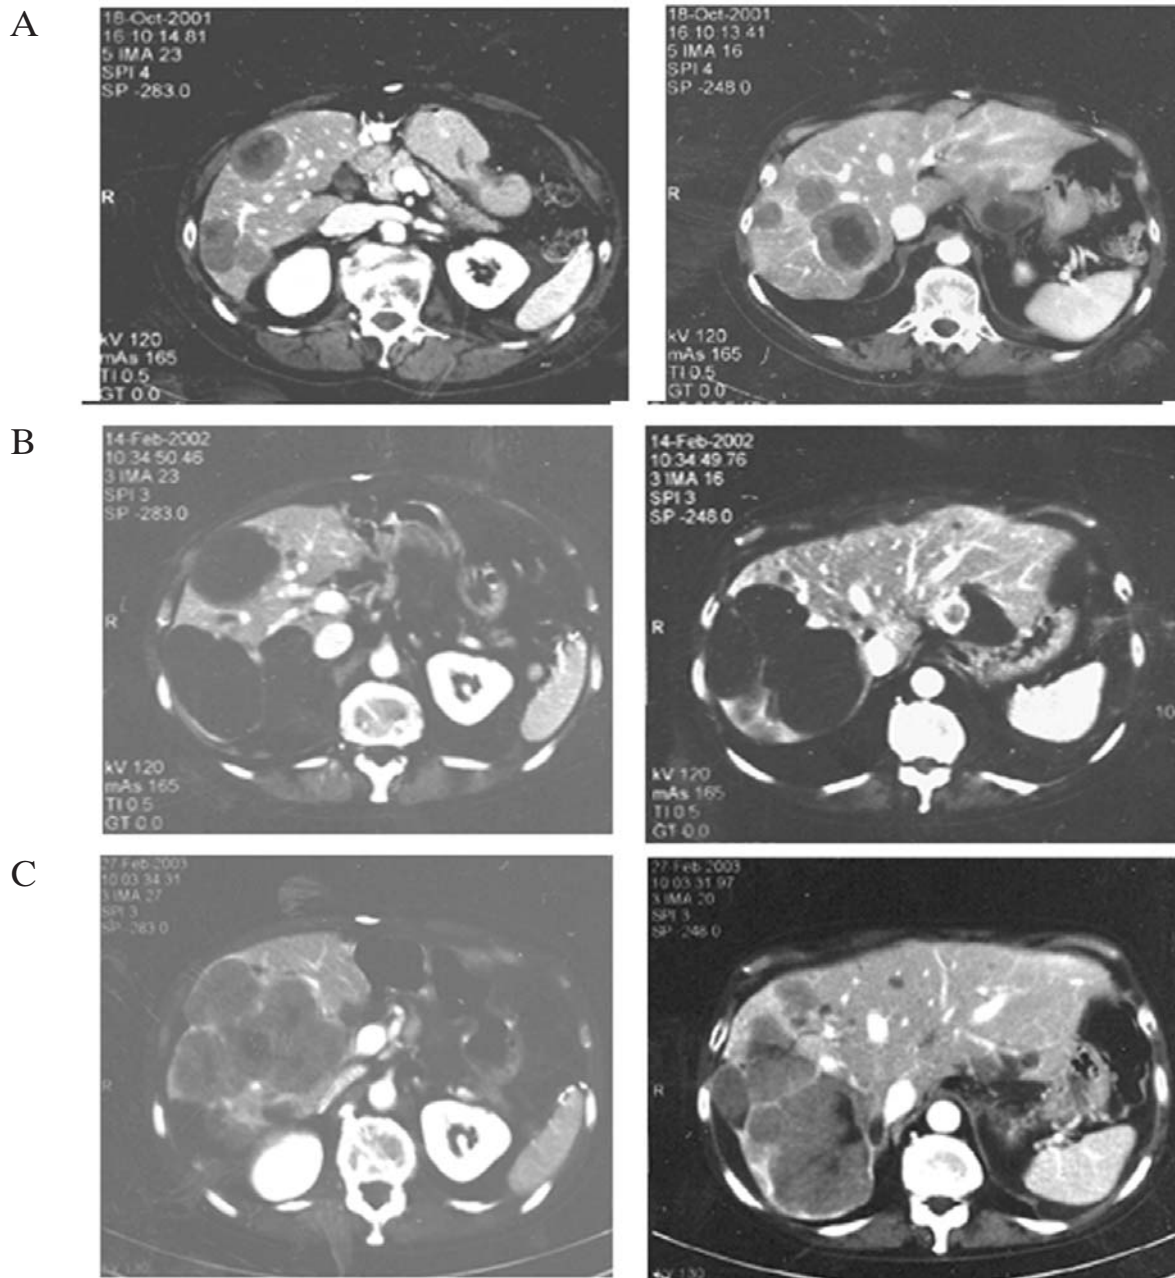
CT scan assessment during treatment with Imatinib. A: Abdomen-pelvis CT scan performed before treatment start. B: After 10 weeks of treatment with oral Imatinib, 400 mg/day. C: Abdomen-pelvis CT scan performed after 14 months of treatment.
